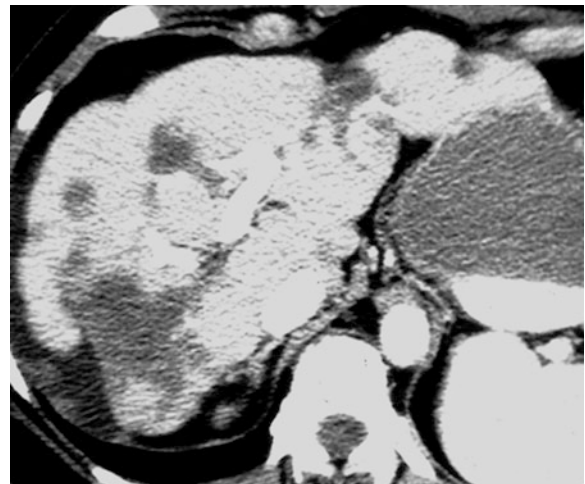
CT scan in a 56-year-old female with breast cancer treated with chemotherapy. Transverse hepatic venous phase image demonstrates diffuse hepatic nodularity and geographic hypoattenuating areas consistent with fibrosis. Findings are of pseudocirrhosis of treated breast cancer metastases; however, without prior studies and clinical history, these findings could suggest diagnosis of cirrhosis
